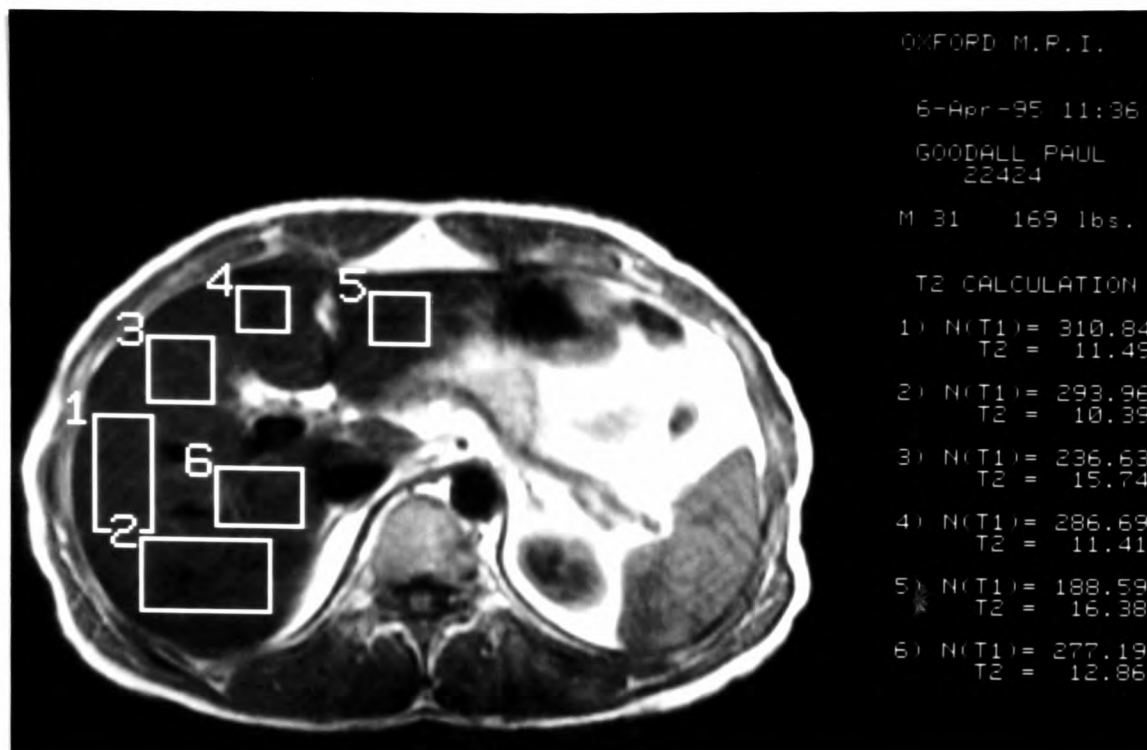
Magnetic resonance imaging (MRI) scan of a patient with haemochromatosis. From a scan such as this the splenic iron concentration can be derived from T2 relaxation data. Combined with estimation of hepatic iron concentration the relative distribution of iron between the two sites can be calculated
